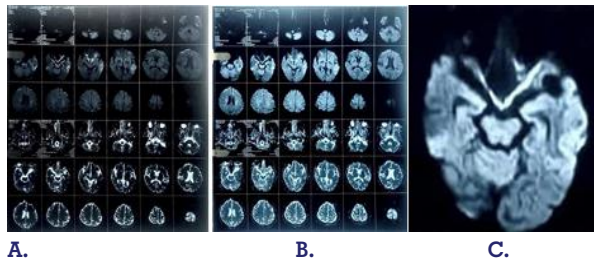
Figure A,B,C: Figure A: T2w MRI Brain. B. DWI MRI Brain. C. DWI MRI Brain section showing Left sided Temporal sclerosis.
